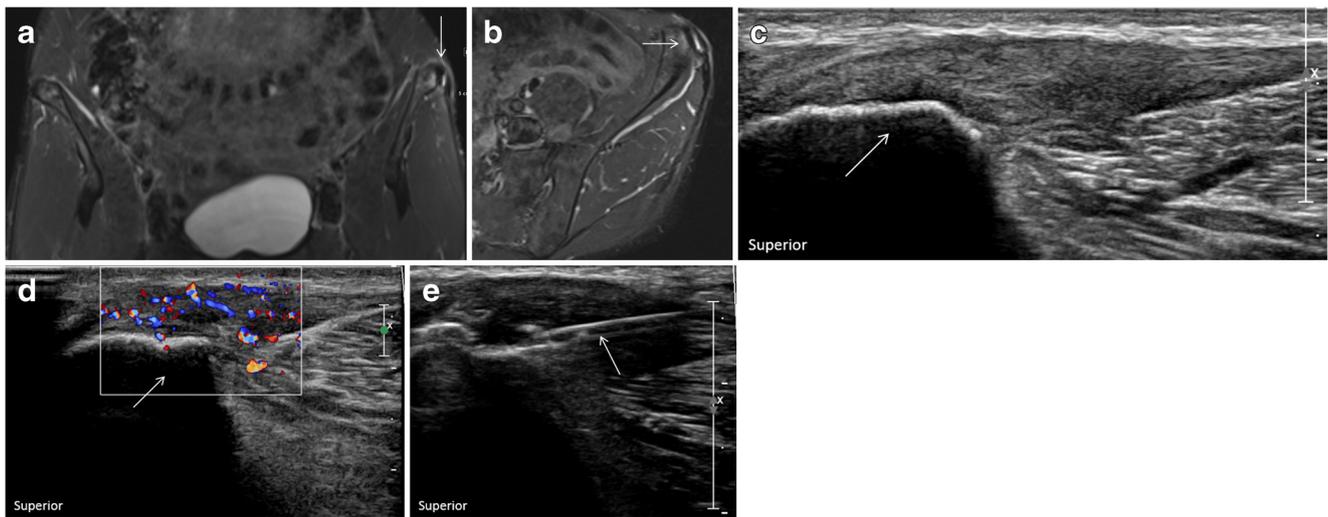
A 52-year-old female runner with left hip pain and tenderness along the medial margin of the iliac tubercle on physical exam. MRI was initially obtained. a Coronal and b axial STIR images demonstrate a high-grade partial-thickness tear of the FLAIC with associated bone marrow edema pattern within the iliac crest (*arrow*). c Longitudinal
